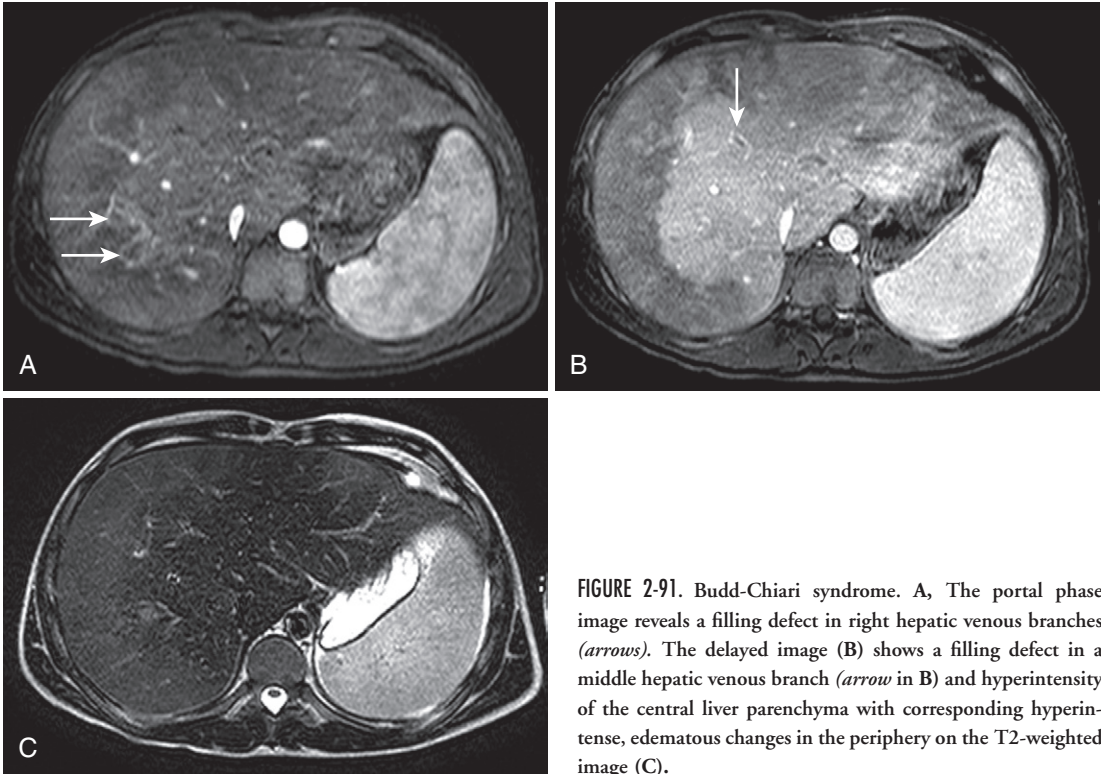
Budd-Chiari syndrome. A, The portal phase image reveals a filling defect in right hepatic venous branches (*arrows*). The delayed image (B) shows a filling defect in a middle hepatic venous branch (*arrow* in B) and hyperintensity of the central liver parenchyma with corresponding hyperintense, edematous changes in the periphery on the T2-weighted image (C).
